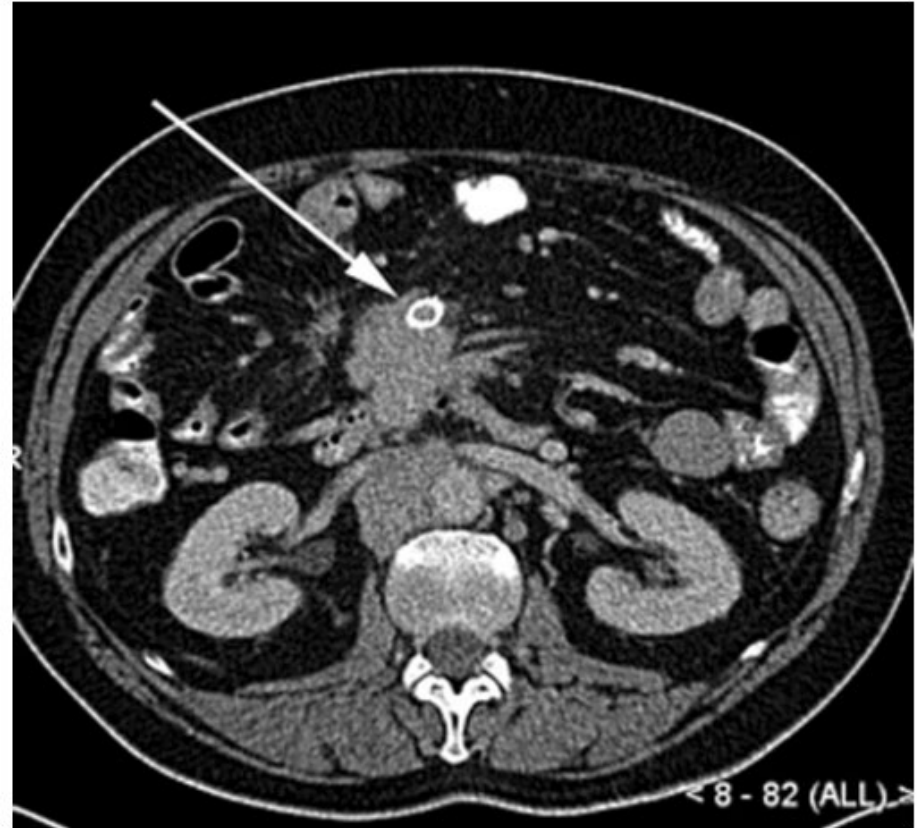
Case 1: A CT scan performed 6 weeks after stenting demonstrates the stent in place (*arrow*), absence of ascites, and normalization of the thickness of the small intestine wall
